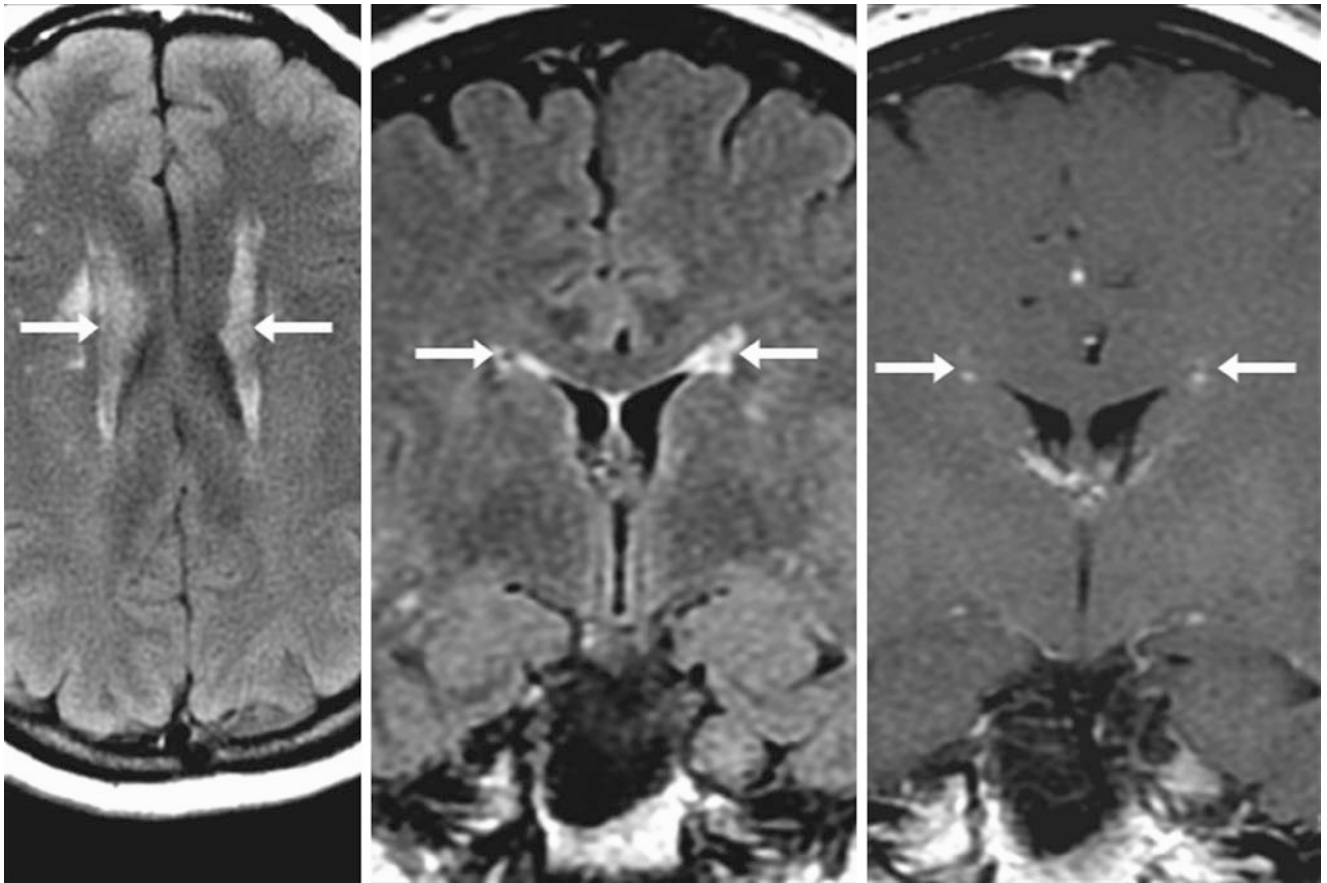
A 56 year old whose images showed asymmetric PEPs (arrows), the left greater than the right on axial (*left*) and coronal (*middle*) FLAIR images. Note the mild underlying periventricular
